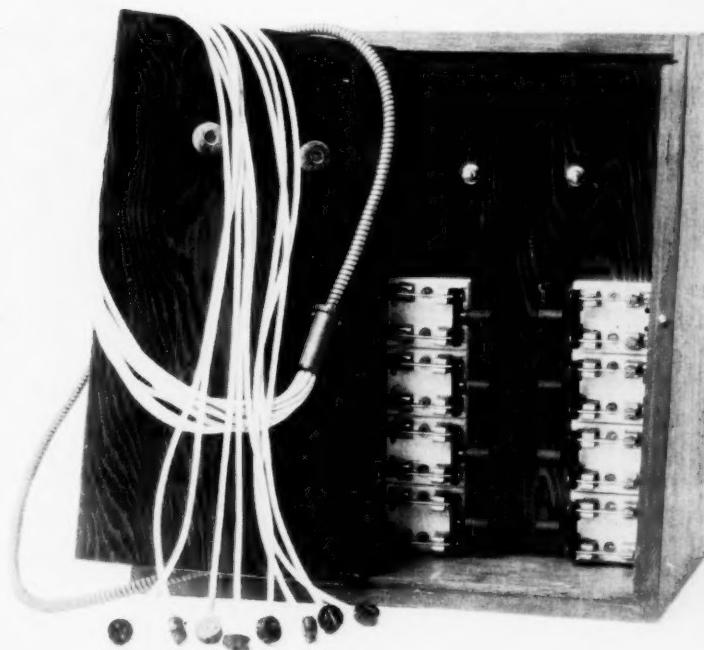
PHOTOGRAPH OF SKIN THERMOCOUPLES AND SWITCHES CONNECTED TO EACH PAIR OF THERMOCOUPLES RESPECTIVELY
